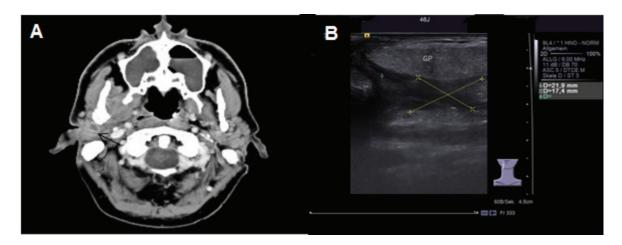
(A) After completion of chemotherapy for the recurrence, axial contrast computed tomography of the head shows a residual intraglandular tumour with central necrosis (arrow). (B) On ultrasonography, a hypoechoic area 22.0×17.5 mm in size was identified in the deep caudal part of the gland, corresponding to the computed tomography findings.
